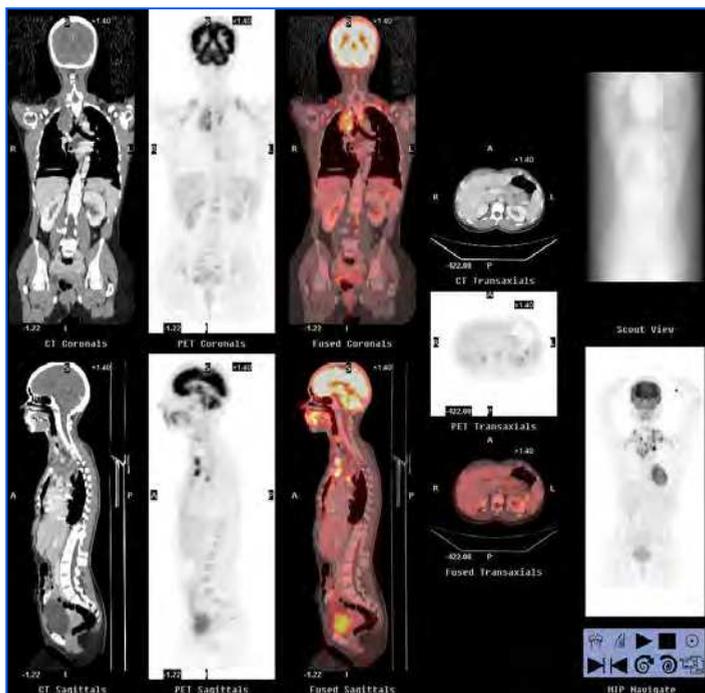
PET/CT can change the stage of the disease in approximately 10% of all lymphoma patients. Study of PET/CT in initial staging of a patient with nodular sclerosis Hodgkin's lymphoma with laterocervical, supraclavicular and mediastinal involvement.
